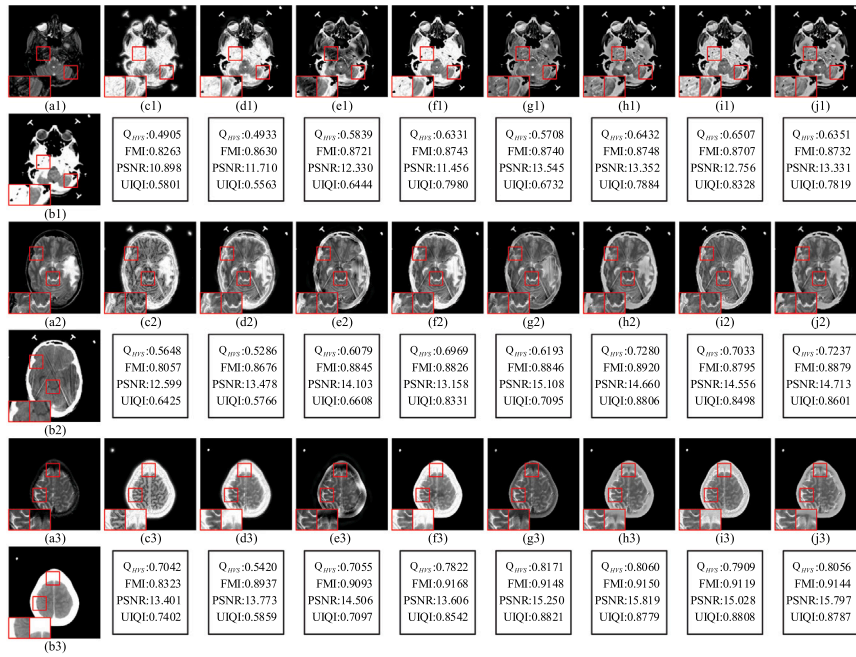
The visual result of various fusion methods on MRI and CT images. The proposed method obtains more competitive results than other methods. Please refer to the main text for more detailed descriptions. The fused images obtained: (a1-a3) MR; (b1-b3) CT; (c1-c3) LLF-IOI; (d1-d3) NSST-PAPCNN; (e1-e3) NSCT-PCDC; (f1-f3) NSCT-RPCNN; (g1-g3) GFF; (h1-h3) CS-MCA; (i1-i3) IFCNN and (j1-j3) DRCL.
